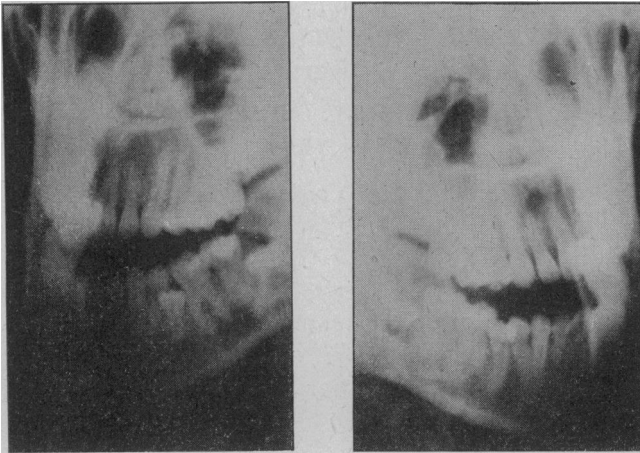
(*Case I*).—Lateral jaw radiographs showing areas of rarefaction over both maxillary lateral incisors. (Radiograph kindly lent by Mr. G. J. Parfitt.)
